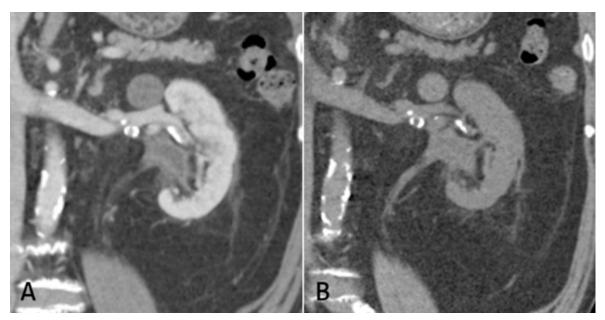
Both 2-month (a) and 14-month (b) follow-up coronal CT images show resolved parapelvic cyst and hydronephrosis.
